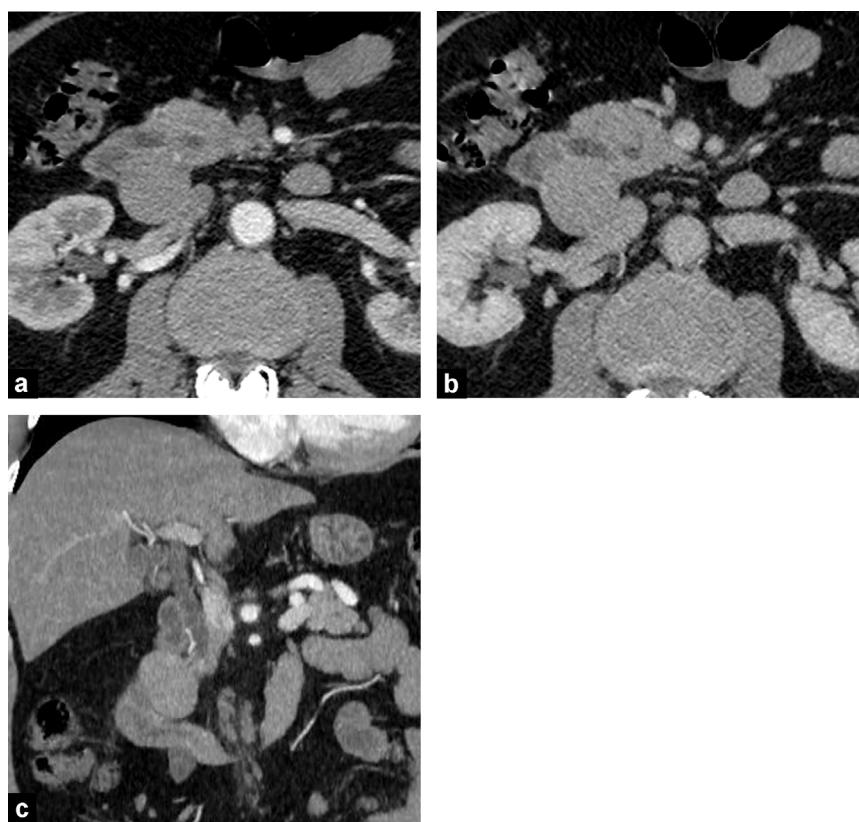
Non-functioning pancreatic neuroendocrine tumor. CT images in the transverse plane during the arterial (a) and portal phase (b) show a large mass developed between the second portion of the duodenum and the pancreatic head. This lesion is not hypervascular on arterial phase and is associated with a dilation of the common bile duct well depicted on the coronal reconstruction (c).
